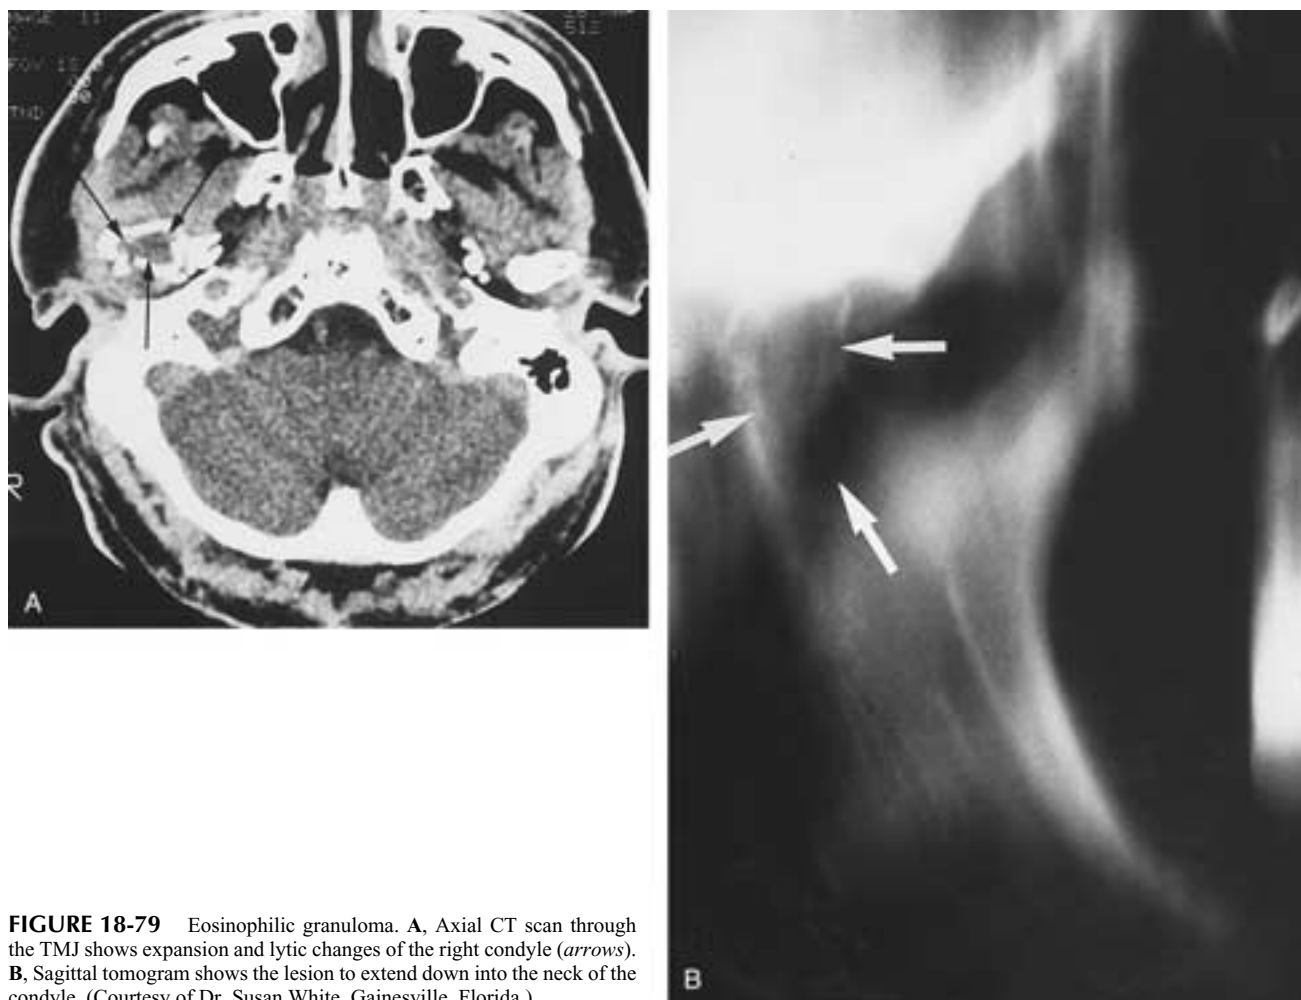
Eosinophilic granuloma. A, Axial CT scan through the TMJ shows expansion and lytic changes of the right condyle (*arrows*). B, Sagittal tomogram shows the lesion to extend down into the neck of the condyle. (Courtesy of Dr. Susan White, Gainesville, Florida.)
